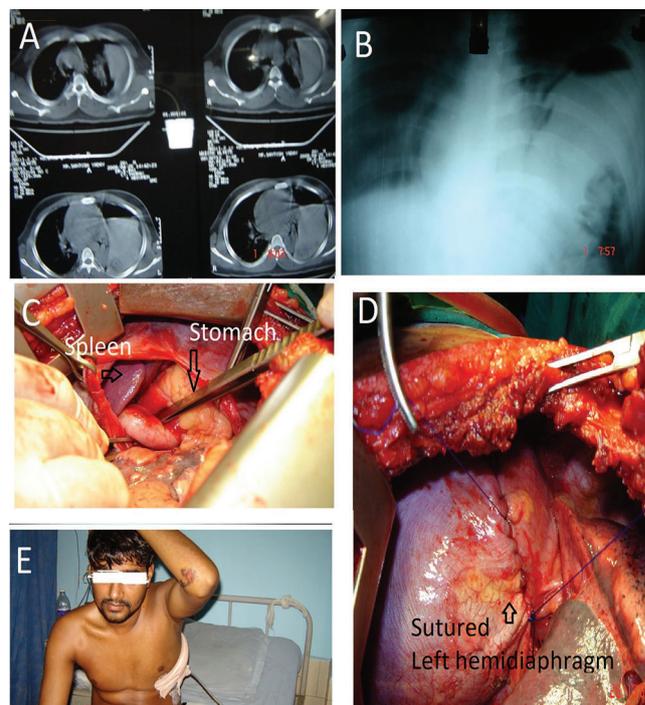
Preoperative imaging, operative findings and post operative photograph of the patient as described in Sl No.2 in Table 1. (A) CT; (B) Chest X- ray of herniated viscera in left hemi thorax; (C) Spleen and stomach after reduction through the ruptured diaphragm held with Babcock's forceps after exploration by left lateral thoracotomy; (D) The diaphragm being sutured in 2 layers with # 1 polypropylene, E. post operative appearance of the patient in the next day. All frames contain explanatory arrow sign for anatomic structures.
